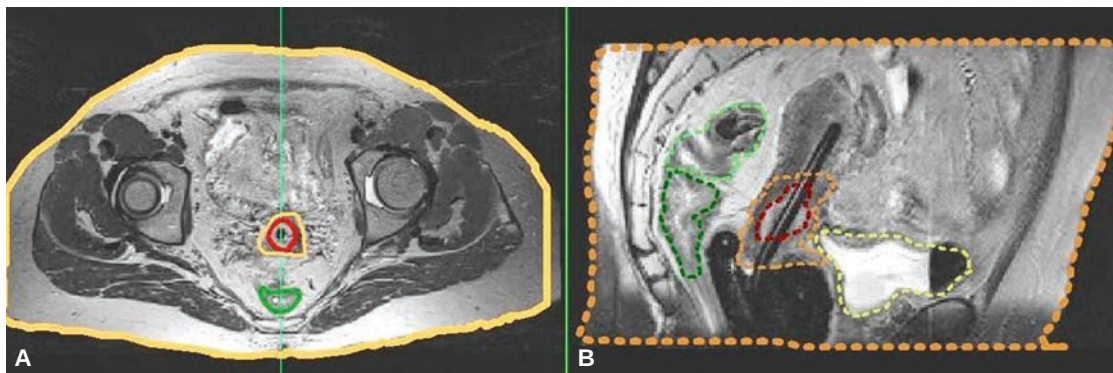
Axial A: and sagittal B: MRI images with MRI compatible applicator in place with contours of the gross target volume (GTV) and high risk clinical target volume (HRCTV) as well as the rectum, sigmoid and bladder.
